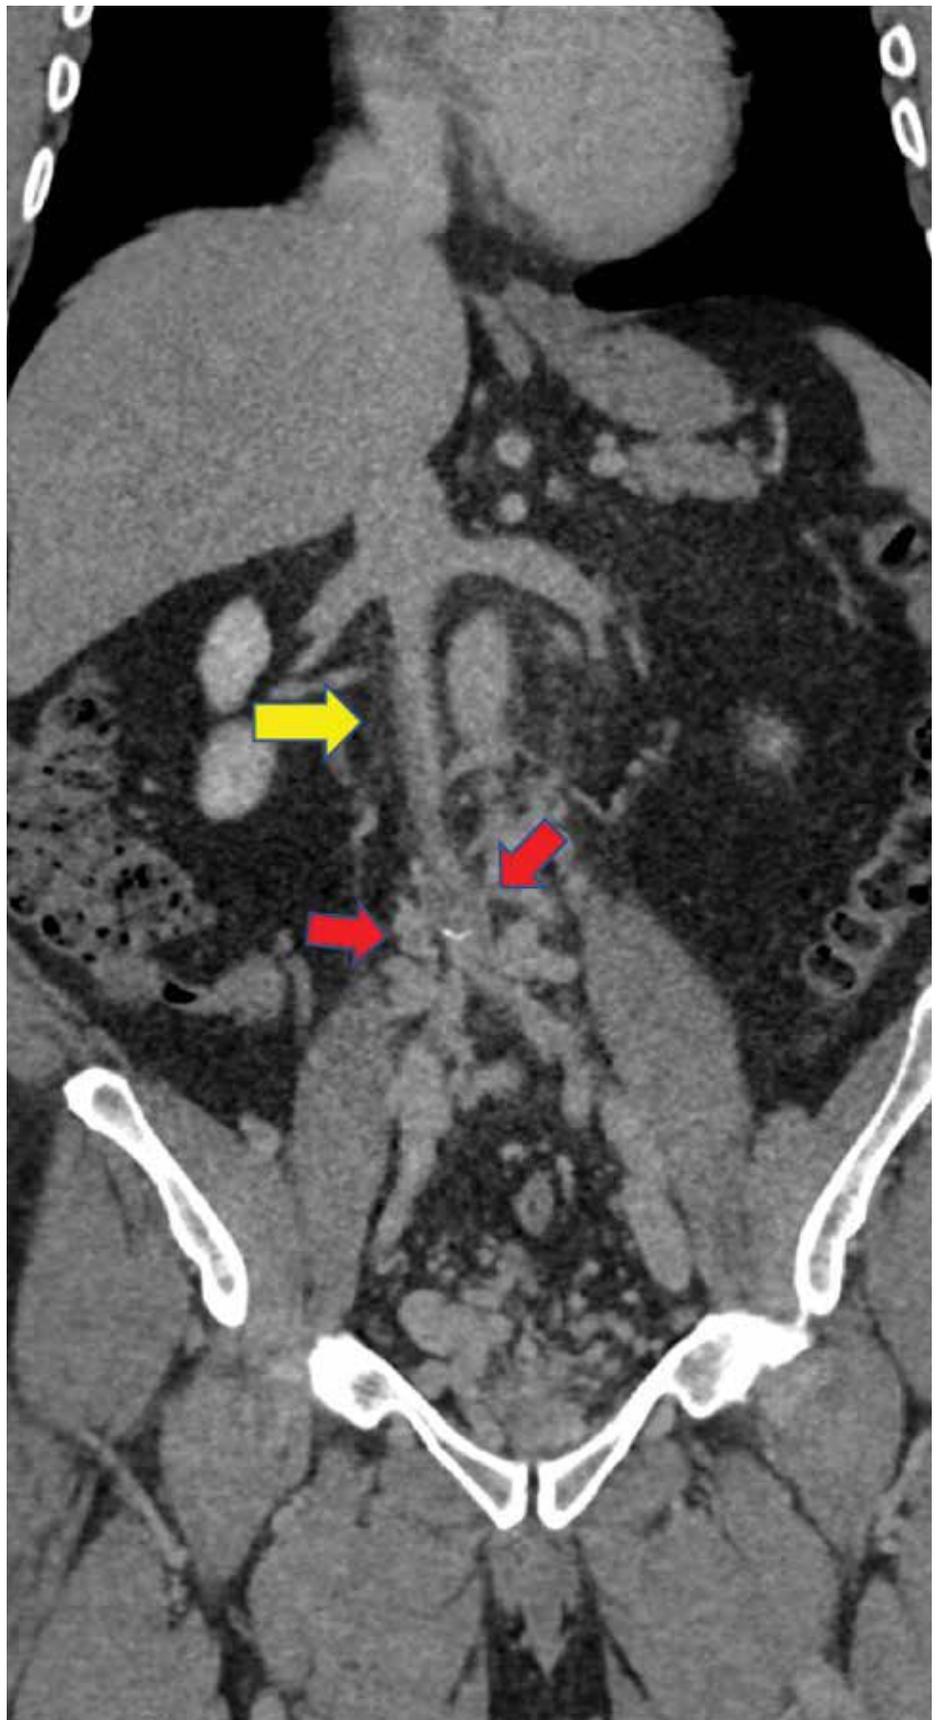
CT scan showing chronic occlusion of the inferior vena cava (yellow arrow) and bilateral common iliac veins (red arrows).
